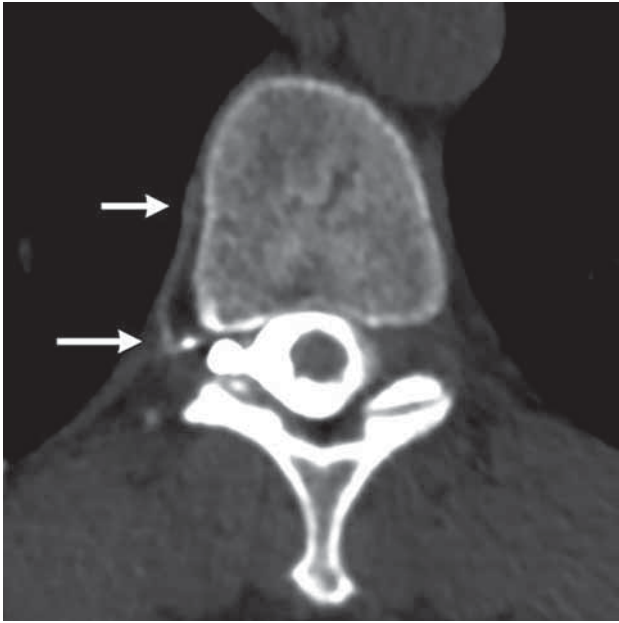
Type 3 CSF leak (CVF): right decubitus CT myelogram in the axial plane shows a paraspinous vein (arrows) that was contiguous with the right T10–T11 meningeal diverticulum.
